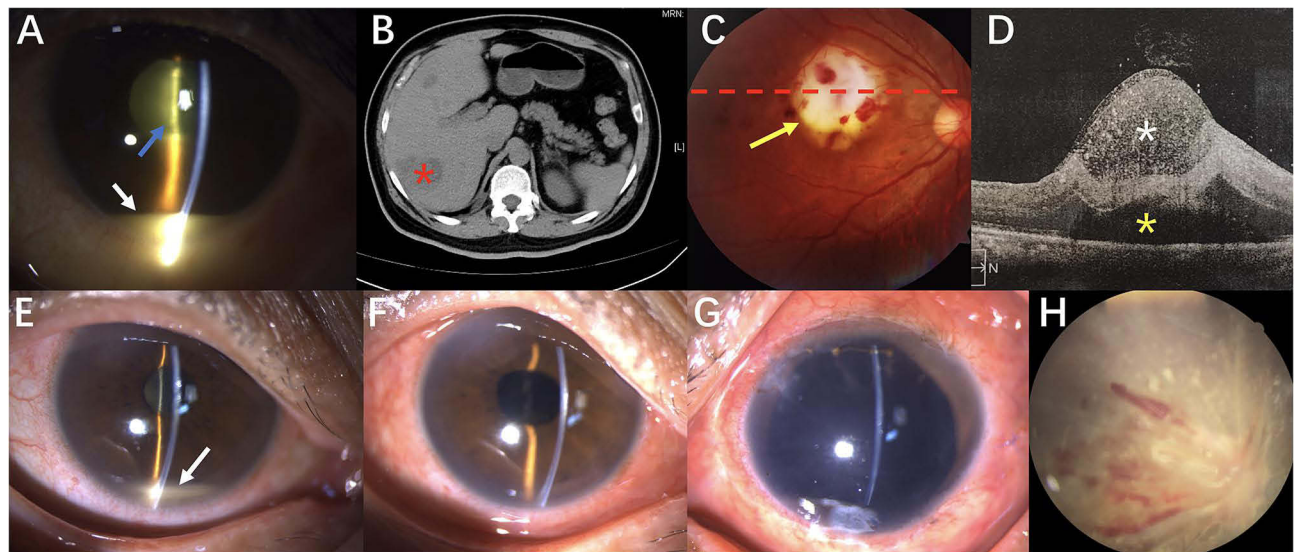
Representative clinical features of *K. pneumoniae* related endogenous endophthalmitis (KPREE) and intraocular surgery related postoperative endophthalmitis (ISRPE). A 61-year-old female (case 3) was diagnosed with KPREE due to 1-day left blurred vision, 3-day eye pain and 10-day fever, at the post-operative 4-month visit of hilar cholangiocarcinoma. (A) The slit-lamp photography showing 2-mm hypopyon (white arrow), cloudy aqueous humor, and severe fibrinous exudates on the surface of the lens (blue arrow). (B) A computed tomography on the abdomen showing a liver abscess with the size of 4 cm in diameter (red asterisk). A 40-year-old male (case 4) was diagnosed with KPREE due to 6-hour right central scotoma following a 2-day fever history, without any past medical history. (C) The color fundus photography showing a yellow-white infectious lesion (yellow arrow) located superior the fovea with a 2-disc diameter size, leaving several bleeding spots around the lesion margin. (D) Optical coherence tomography scanning of the infectious lesion along the red dotted line in C showing a highly reflective signal (white asterisk) and subretinal fluid (yellow asterisk). A 64-year-old female was diagnosed with ISRPE due to 1-day right sudden vision loss, following a prior 3-day history of cataract phacoemulsification combined with intraocular lens implantation, without previous diabetes. (E) The slit-lamp photography showing congested conjunctiva, 1-mm hypopyon (white arrow), and cloudy aqueous humor. (F) Slit-lamp photography at the 2-week visit after intravitreal injection (1 mg of vancomycin) showed absence of hypopyon. A 48-year-old male (case 5) was diagnosed with KPREE due to 5-day left decreased vision with eye redness and pain, following 4-day fever, with a 1-year uncontrolled diabetes history (with plasma hemoglobin A1C of up to 9.4% and maximum IOP of 35 mmHg). (G) Slit-lamp photography at the 1-month follow-up showing severe iridocolobom, aphakia, and intraocular silicone oil tamponade. (H) Color fundus photography taken on the same day as shown in G showing a pale retina, superficial flame-like hemorrhage, and complete retinal vascular whitening.
